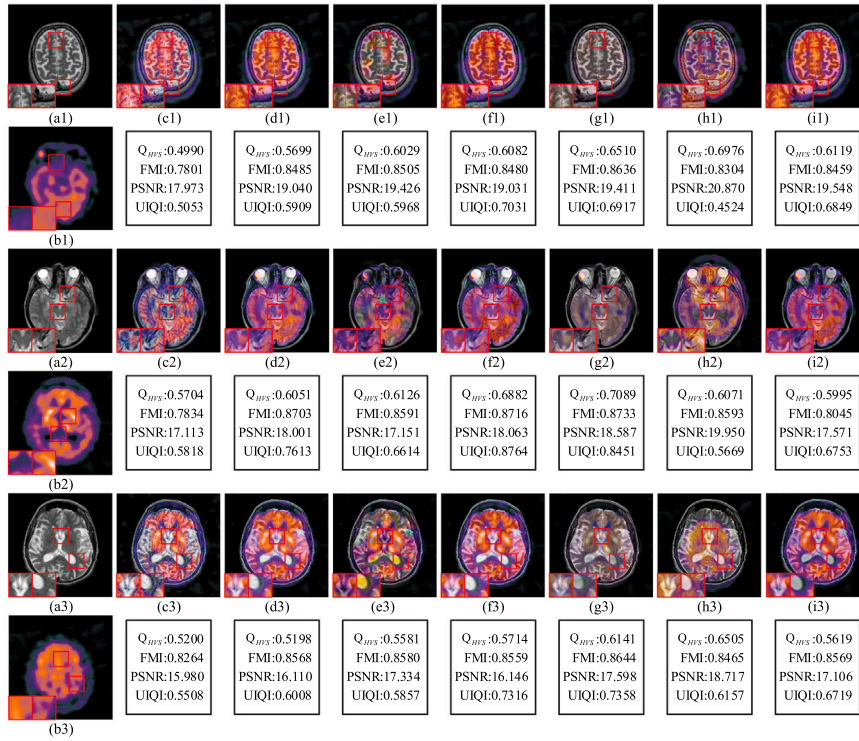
The visual result of various fusion methods on MRI and SPECT images. The proposed method obtains more competitive results than other methods. Please refer to the main text for more detailed descriptions. Fused images obtained: (a1-a3) MRT; (b1-b3) SPECT; (c1-c3) LLF-IOI; (d1-d3) NSST-PAPCNN; (e1-e3) NSCT-PCDC; (f1-f3) NSCT-RPCNN; (g1-g3) GFF; (h1-h3) IFCNN and (i1-i3) DRCL.
